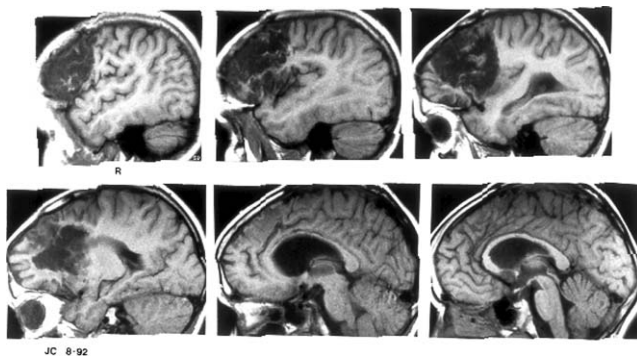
Sagittal view of JC's lesion on brain MRI.
